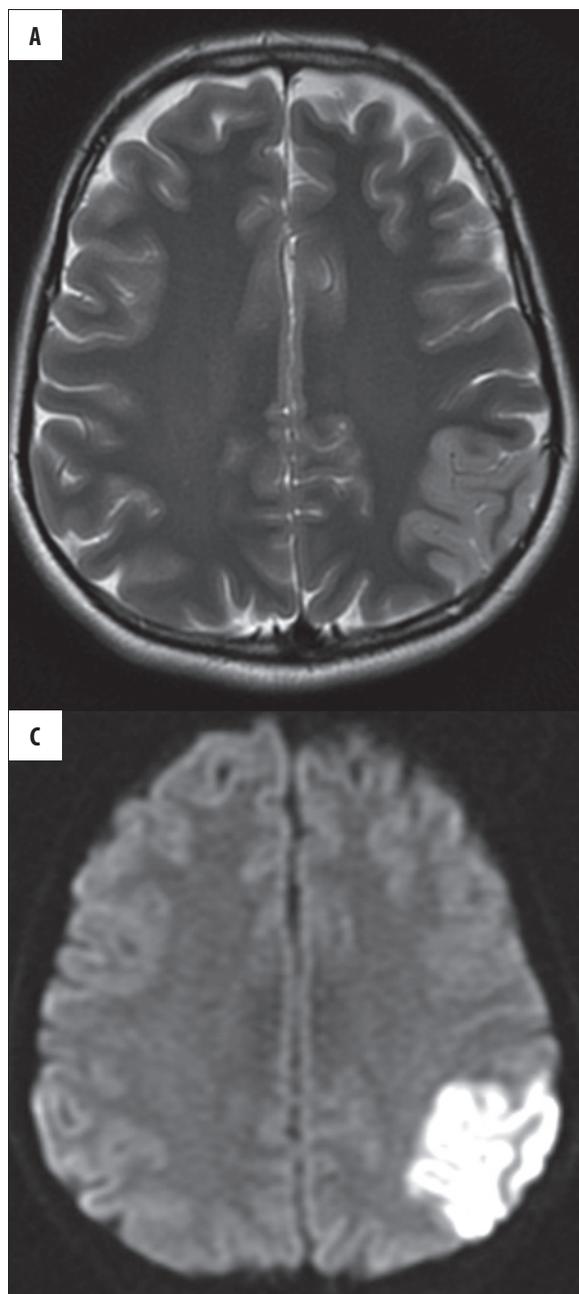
Patient with an arterial ischemic infarction. MR images without contrast injection on the 3rd day after the onset of neurological symptoms: (A) – T2-weighted, (B) – FLAIR images and (C) – DWI. The infarction is seen as a hyperintense lesion on T2-weighted and FLAIR images with strong diffusion restriction (C) typical for cytotoxic edema.
